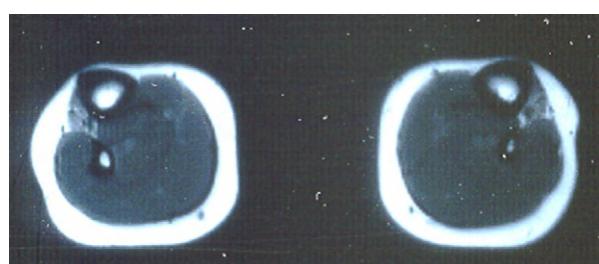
Distal nebulinopathy. Magnetic resonance imaging of muscle of the lower legs in a 24-year-old woman with early-onset distal myopathy caused by a homozygous missense mutation in nebulin, showing selective lesions in anterior tibialis muscles bilaterally.
